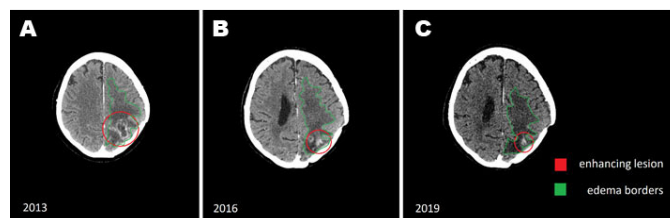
Brain contrast enhanced CT. (A) From year 2013—ring enhancement focus in occipital lobe of left hemisphere accompanied by 2nd degree edema. (B) From year 2016—significant regression of ring enhancement, only weak enhancement was visible in the tumor bed, accompanied by edema similar to previous examinations, ring enhancement, which had been visible before was not found at present CT, mass effect was not found. (C) From year 2019—both the level of enhancement and edema extent are consistent with 2016 CT.
